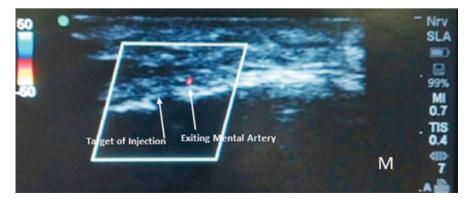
Ultrasound guided mental nerve block
